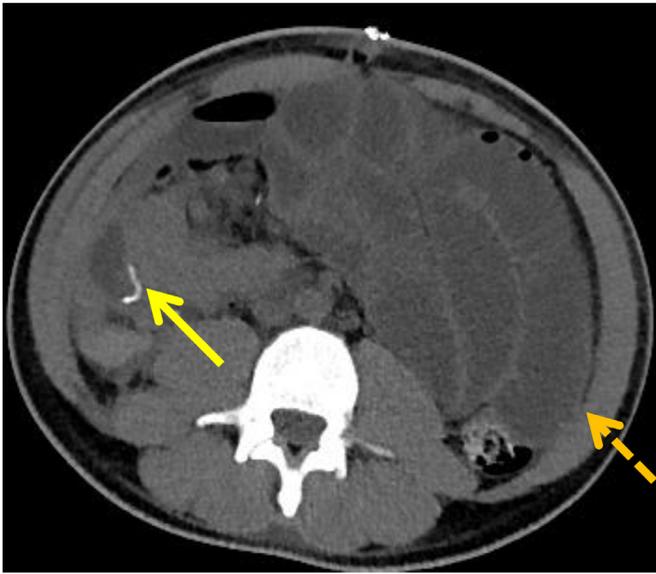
Post-transplant small bowel obstruction may occur due to a complication related to the bowel anastomosis of pancreatic enteric drainage. This 22-year-old male demonstrates multiple dilated small bowel loops (dashed arrow), with a transition point (solid arrow) noted at the level of the suture between the pancreatic graft and small bowel, on this non-contrast CT image, likely secondary to a stricture at the anastomosis. (Color version of figure is available online.)
